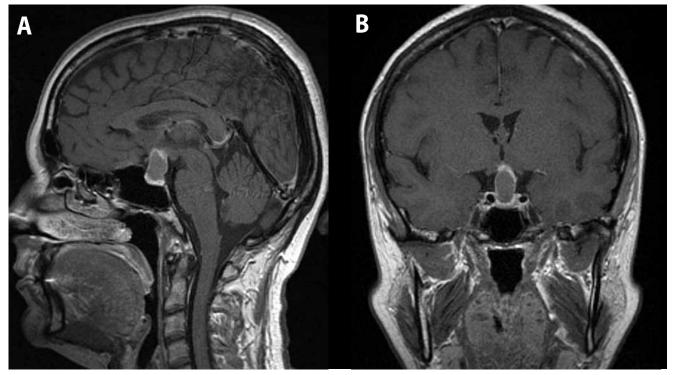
Preoperative sagittal (A) and coronal (B) view T1 weighted gadolinium-enhanced MR images reveals isointense lesion in the sellar region with partial thin rim enhancement.
